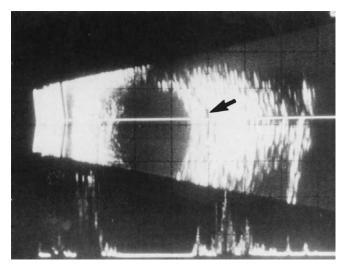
B-scan ultrasonogram of posterior scleritis demonstrating the edematous zone *(arrow)* produced by the posterior scleritis.
